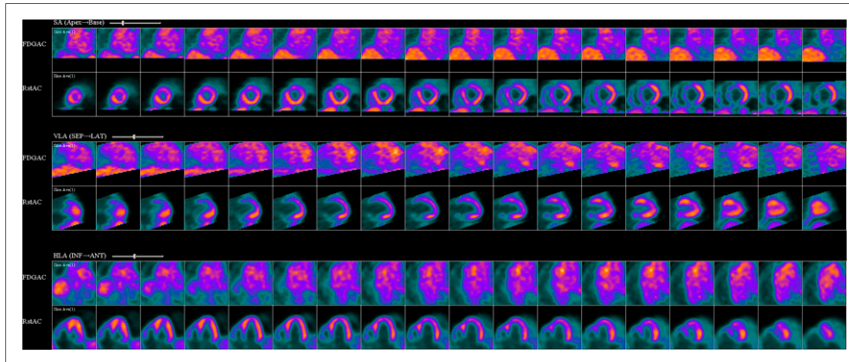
Improvement of perfusion defects as indicated by only blood-pool activity being seen on ^{18}F -FDG images.
